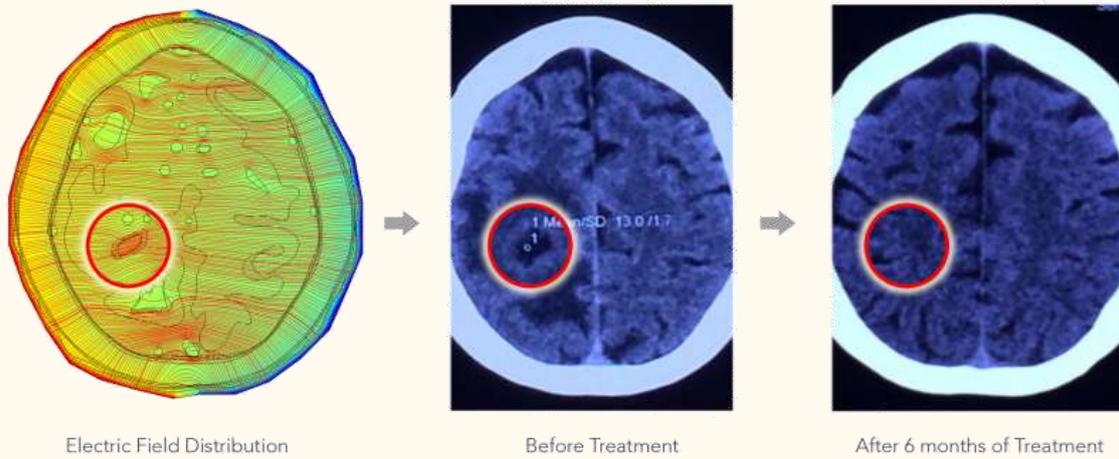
General procedure of ECCT treatment for brain cancer: the electric field computation and subsequent CT scan images of the brain cancer before and after ECCT treatment.
